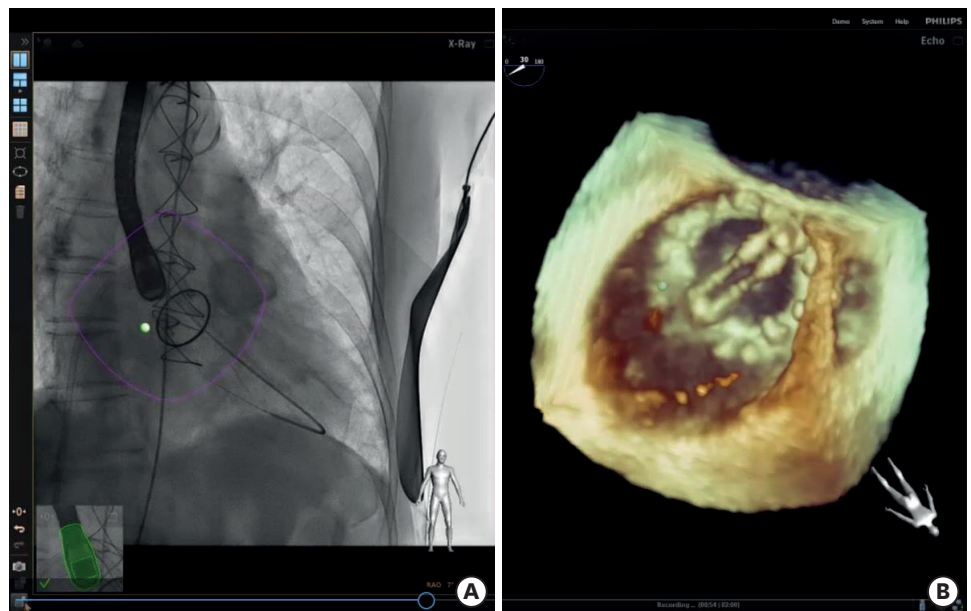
Fusion image from the EchoNavigator System (Phillips Healthcare, Best, The Netherlands) during the procedure. Green dot, demonstrated on fluoroscopic view (A), was marked from the real-time 3-dimension transesophageal echocardiography image (B). The guide wire was targeted to the green dot on fluoroscopic view and was successfully passed through the slit.
